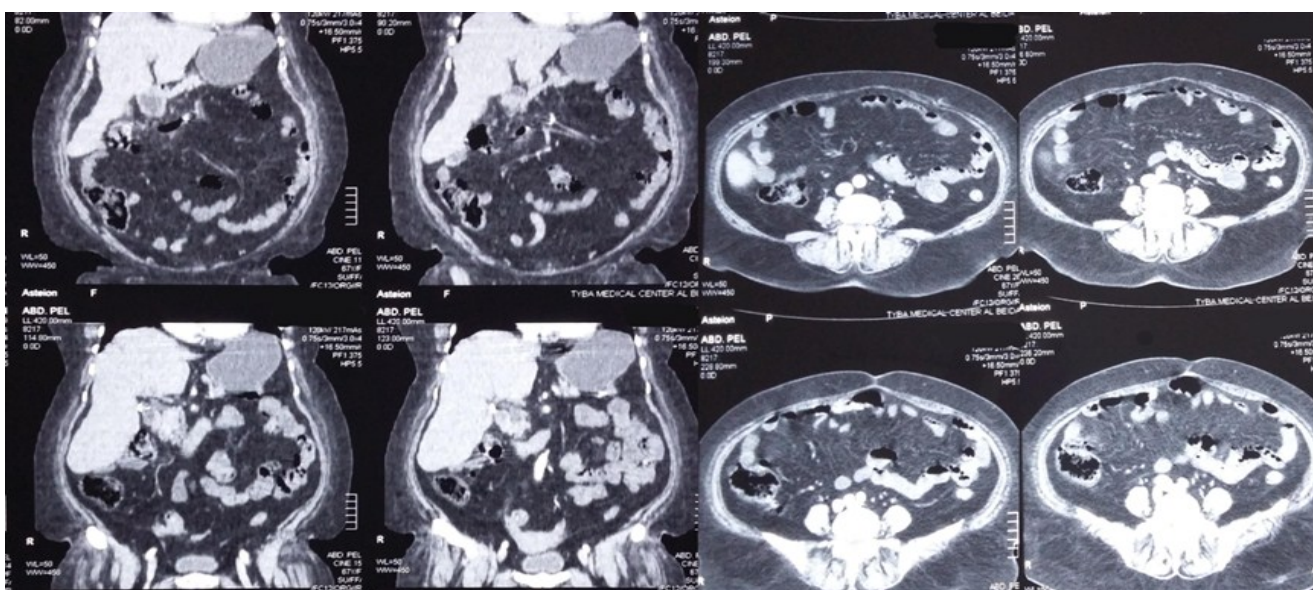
Abdominal pelvic CT scan with contrast showing resolution of mesenteric panniculitis (coronal and cross-sectional views).
